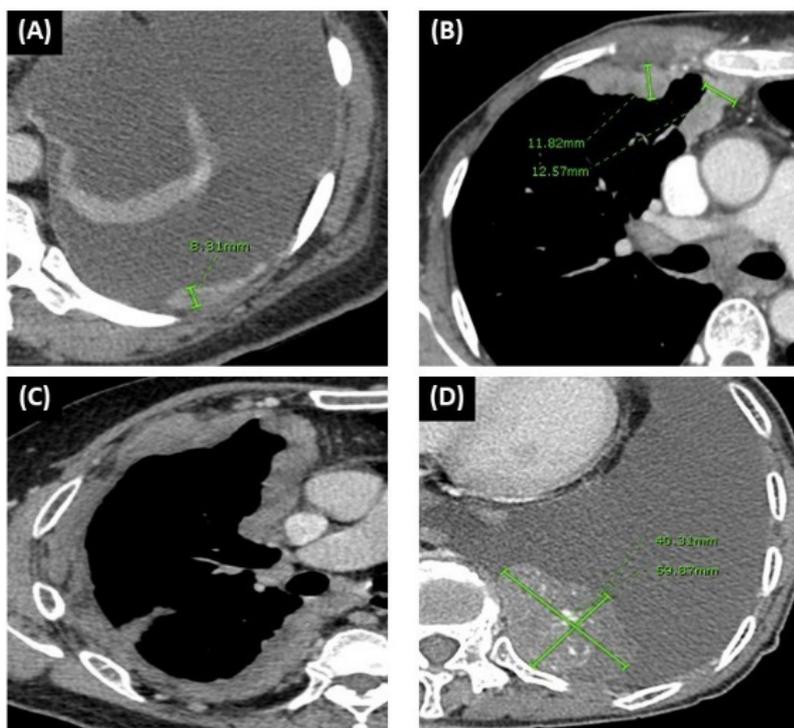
CT scan images show four patterns of pleural thickening. (A) *Thin pleural thickening*: smooth pleural thickening with a maximal thickness on axial scan of less than 1 cm, and involving not more than 3/4 of the hemithorax on axial scan. (B) *Thick/nodular pleural thickening*: pleural thickening with a maximal thickness of greater than 1 cm, but less than 3 cm, and involving not more than 3/4 of the hemithorax on axial scan or discrete pleural nodules. (C) *Circumferential pleural thickening*: continuous pleural thickening involving more than 3/4 of hemithorax on axial scan. (D) *Pleural mass*: pleural lesion with a short axis larger than 3 cm on axial CT scan.
